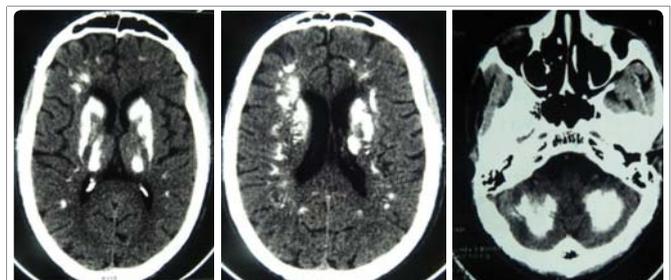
CT scan in axial section, without injection of contrast medium, showing bilateral and symmetrical calcifications, in D on the basal ganglia (lenticular nuclei, caudate nuclei and thalami heads), in E on the body caudate nuclei, the junction white-gray substance, and F on the cerebellar hemispheres (serrated nuclei).
